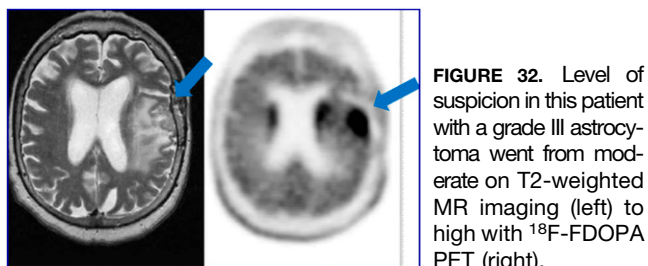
Level of suspicion in this patient with a grade III astrocytoma went from moderate on T2-weighted MR imaging (left) to high with ^{18}F -FDOPA PET (right).
